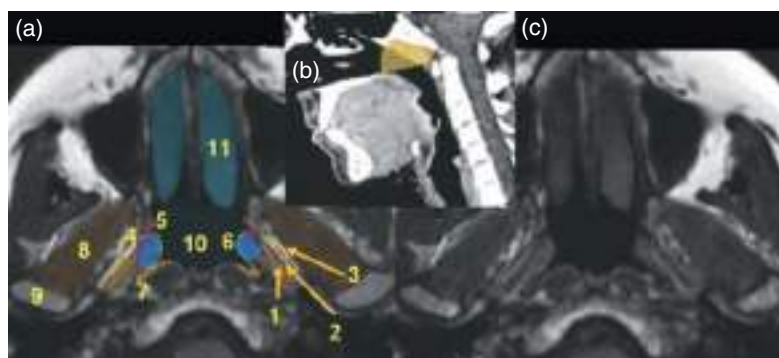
Nasopharynx. Axial T1-weighted MRI at the level highlighted in yellow. 1, levator veli palatini muscle; 2, pharyngobasilar fascia; 3, tensor veli palatine muscle; 4, parapharyngeal space; 5, recess of the Eustachian tube; 6, torus tubarius; 7, fossa of Rossemüller; 8, pterygoid muscles; 9, mandibular condyle; 10, lumen of the nasopharynx; 11, middle turbinate of the nasal fossa.
